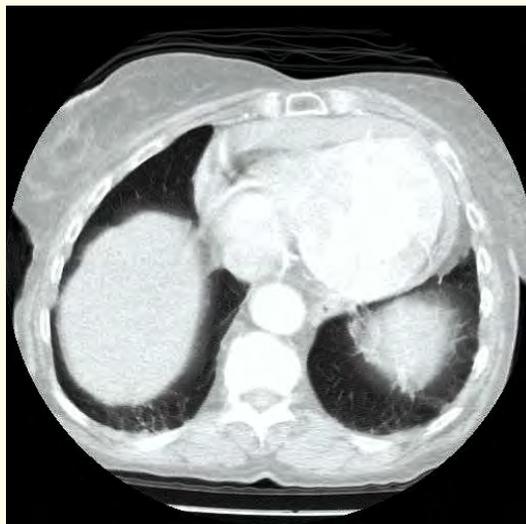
Hemopericardium (CT).
